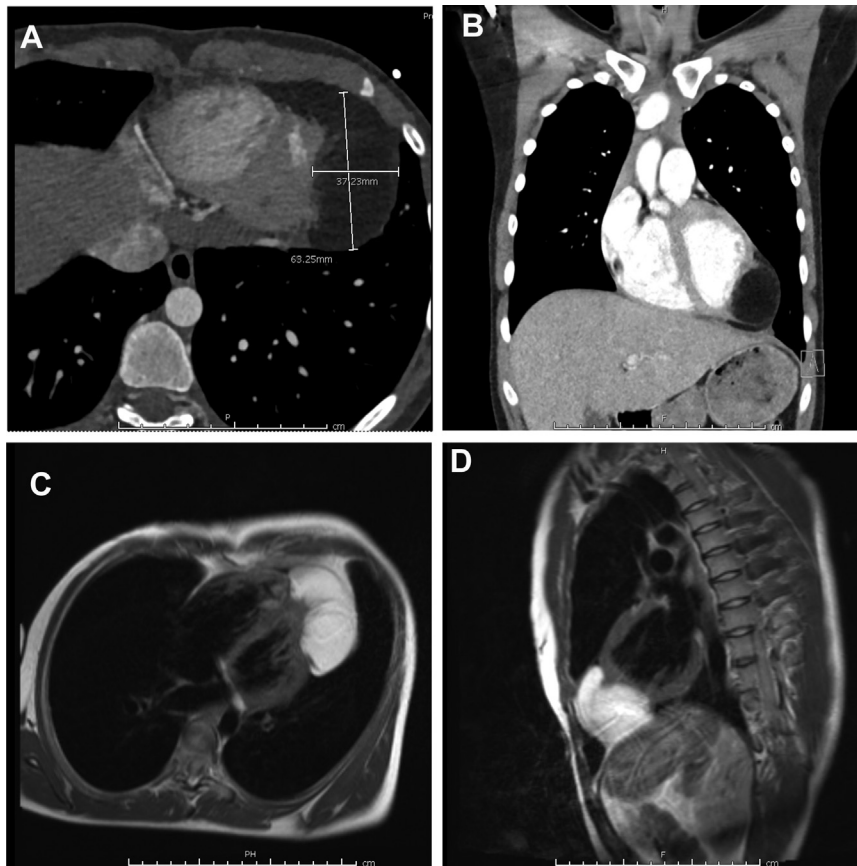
A, B: Cardiac computed tomography demonstrating the echogenic density as a 6.3×3.7 -cm ill-defined fat-density lesion, likely a pericardial and less likely intracardial lipoma, owing to internal minimal stranding and septation, noted to be abutting the inferior left ventricular wall and causing irregularity and mass effect upon the cardiac apex. C, D: Cardiac magnetic resonance imaging showing the lesion to be most consistent with a lipoma, with fat suppression best appreciated on the T2-weighted images.
